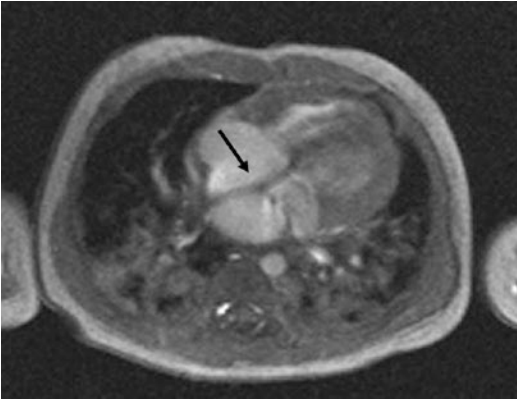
Obstructive cor triatriatum at MRI. Four-chamber view image obtained from cine FLASH MRI sequence shows an obstructive membrane (*black arrow*) dividing the left atrium into proximal and distal chambers. Pulmonary parenchymal edema was also noted
